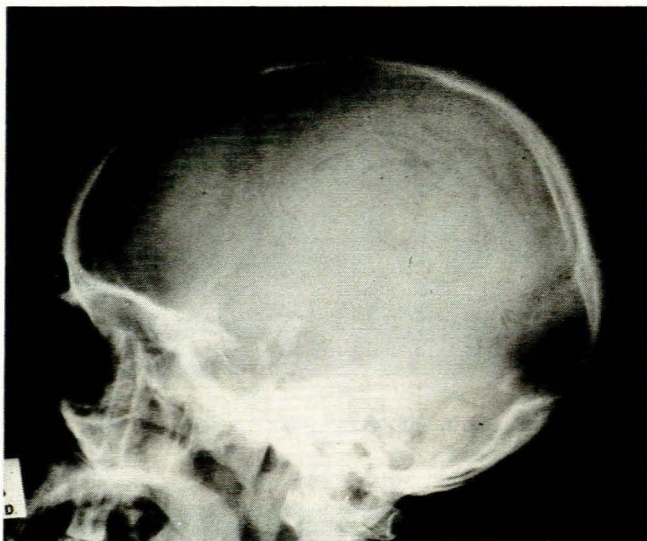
Skull radiograph showing bean-shaped calcifications.
